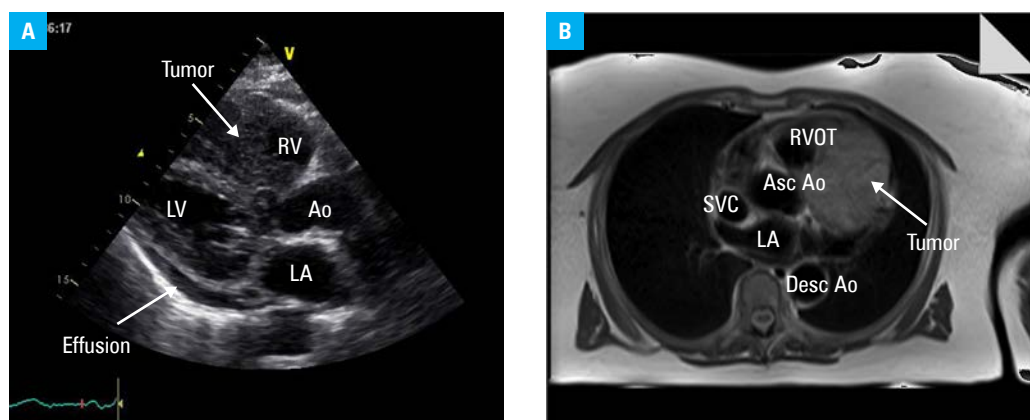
A – a transthoracic echocardiography showing pericardial effusion with a large mass protruding to the right ventricular outflow tract (RVOT); B – axial, T1-weighted black-blood magnetic resonance images showing a large mass located in the RVOT
